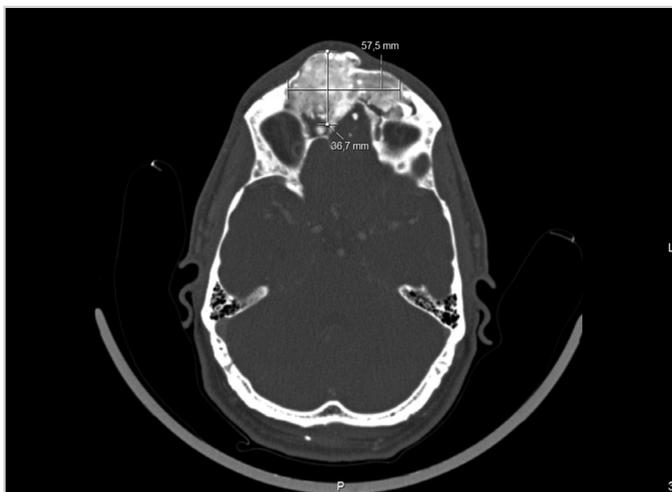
CT scan (axial plane) showing marked dysmorphism of the anterior and right paramedian aspect of the face, which was due to multiple bony structures of nodular features that occupied the right nasal fossa, the bilateral ethmoidal cells and the frontal sinuses, conditioning enlargement of the sinus cavities, with extension into the right orbit. The maximum diameter of the mass was approximately 60 mm to 40 mm
